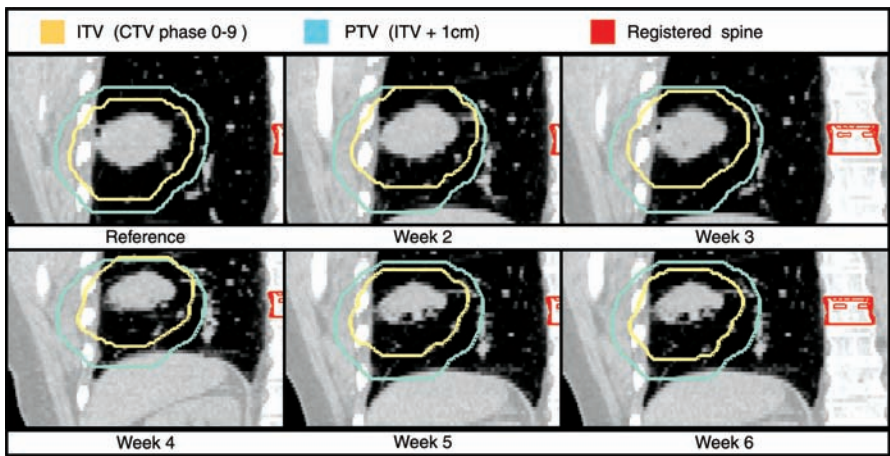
4D-CT scans showing the intrafractional effects of tumor motion on the dose distributed by IMRT. Please refer to full legend on page 74.
